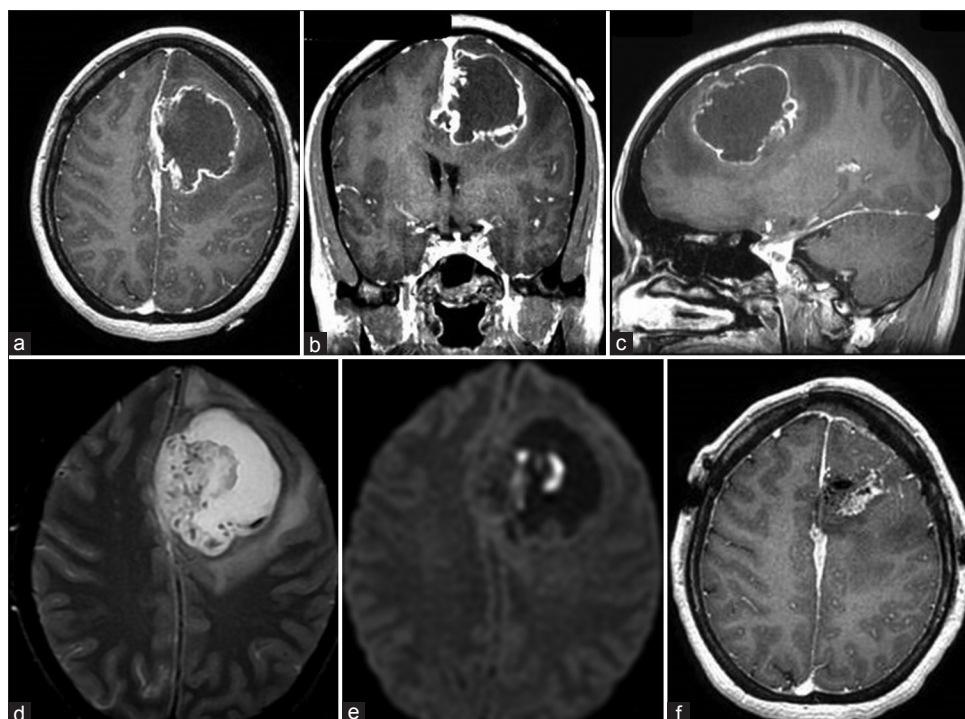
T1-weighted magnetic resonance images (a-c), T2-weighted magnetic resonance image (d), diffusion-weighted magnetic resonance imaging (e), postop magnetic resonance imaging (f)
